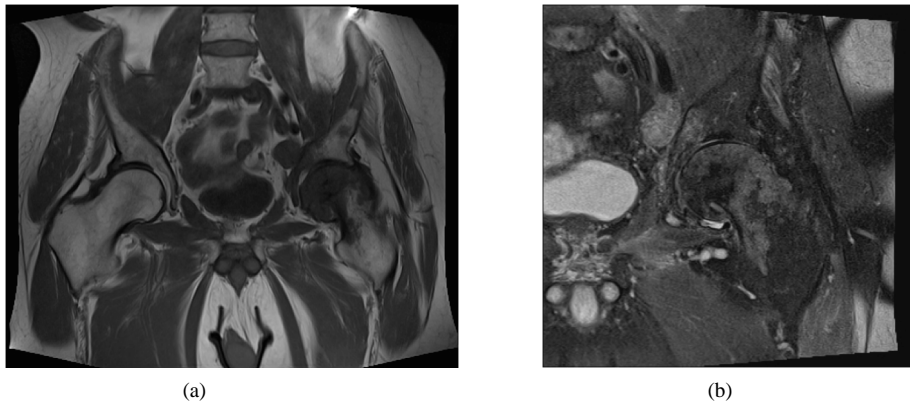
MRI (a) sagittal T1-weighted image of pelvis; (b) sagittal T2-weighted image of the left hip demonstrated a subcapital femoral neck pathologic fracture with surrounding marrow replacement of the femoral neck as well as femoral diaphysis, sacrum, ilium, ischium and acetabulum.
